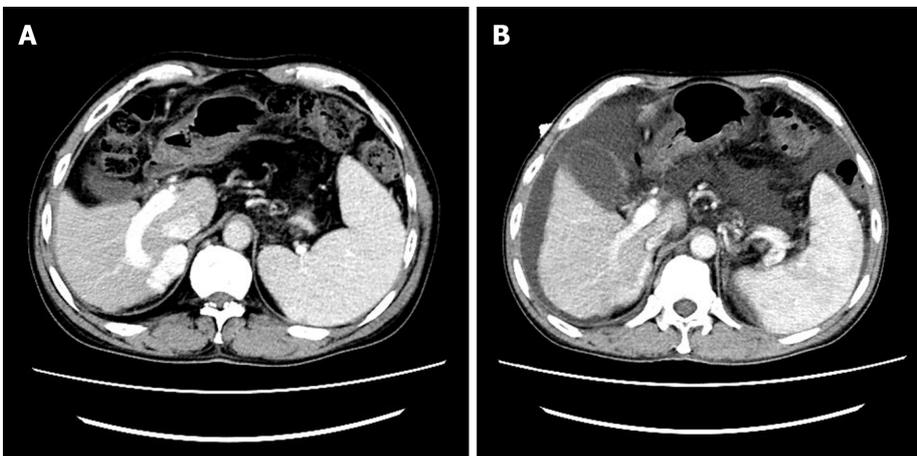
Appearance of intrahepatic portosystemic venous shunt in computed tomography-angiography. (A and B).
